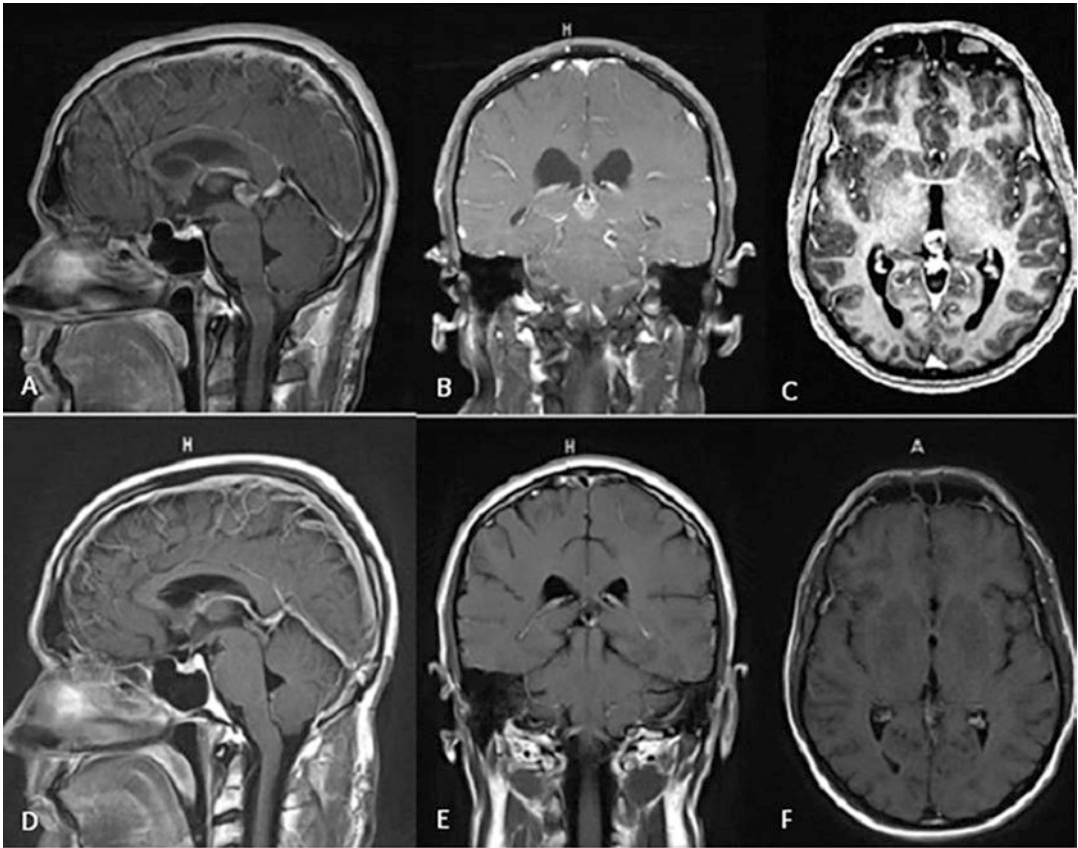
A 31-year-old patient with diplopia and Parinaud syndrome. (a) preoperative T1-weighted post-contrast MRI of the brain, sagittal view, which shows lesion in the pineal region (germinoma), (b) coronal view; note the enlarged ventricles due to occlusive hydrocephalus; (c) axial view. (d) postoperative T1-weighted post-contrast MRI of the brain, sagittal view, which shows the complete
